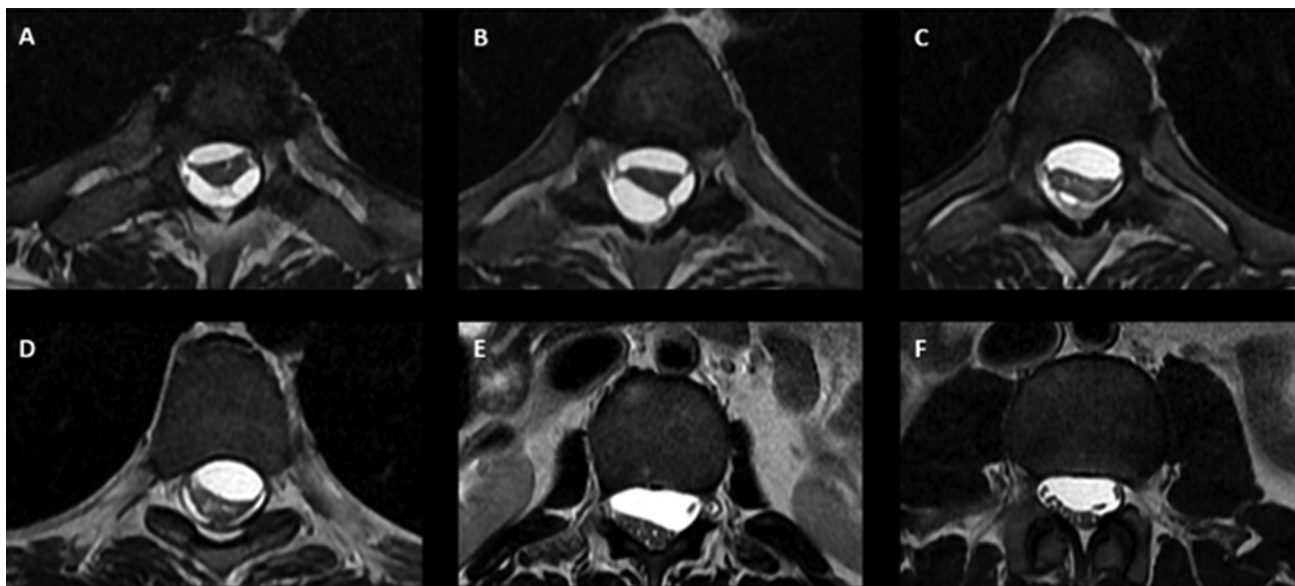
(A–D): Axial T2-weighted MRI showing adhesive arachnoiditis and septations distorting the spinal cord at the level of the thoracic spinal cord; (E,F) axial T2-weighted MRI showing adhesive arachnoiditis and septations distorting the spinal cord at the level of the lumbosacral spinal cord.
